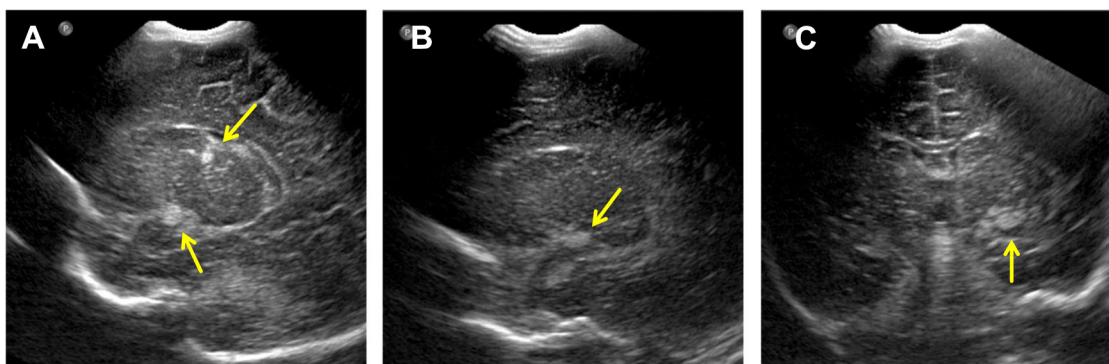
Neonatal transfontanellar ultrasound images in left parasagittal (A, B) and coronal (C) planes demonstrate echogenic lesions in the left thalamus and left choroidal fissure (arrows).
